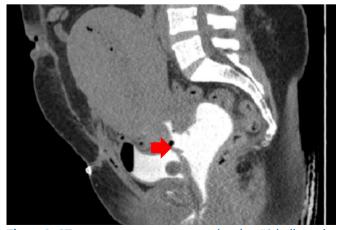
CT cystogram on post-operative day #1 indicated a defect measuring approximately 1.2 cm in width in the posterior wall of the urinary bladder with pooling of contrast in the vagina and lower uterine cavity.
